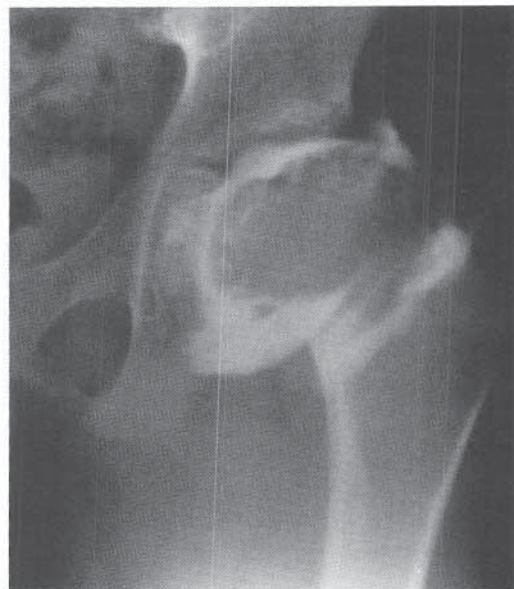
Arthrogram of the left hip of the 9-year-old child whose x-rays are shown in Figure 29-34. Articular irregularity can be seen.
